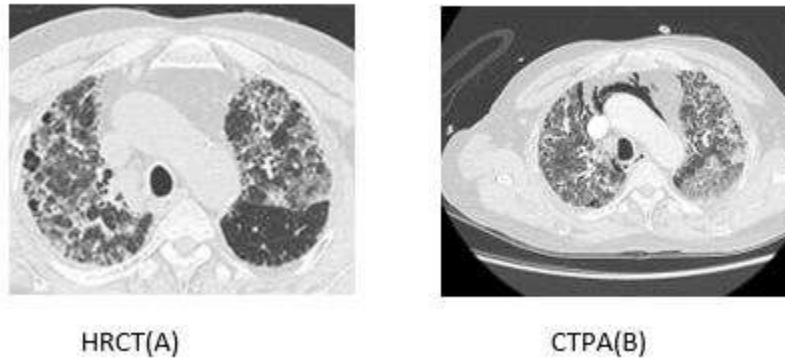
HRCT(A) and CTPA(B) at the level of aortic arch trunk showing pneumomediastinum in CTPA
